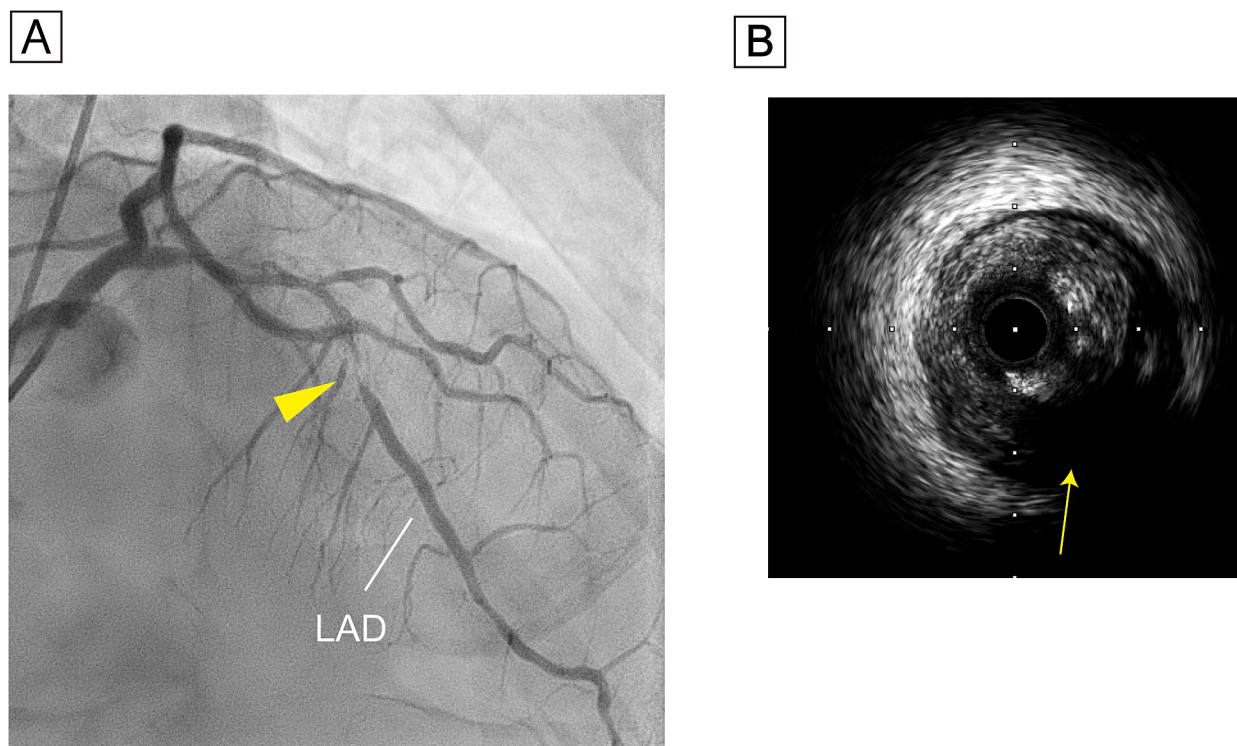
Coronary angiography and intravascular ultrasound. (A) Coronary angiography revealed a severe stenosis of the LAD (arrow head). (B) Intravascular ultrasound showed low attenuation plaque in the LAD without heavy calcification (arrow). LAD, left anterior descending artery.
